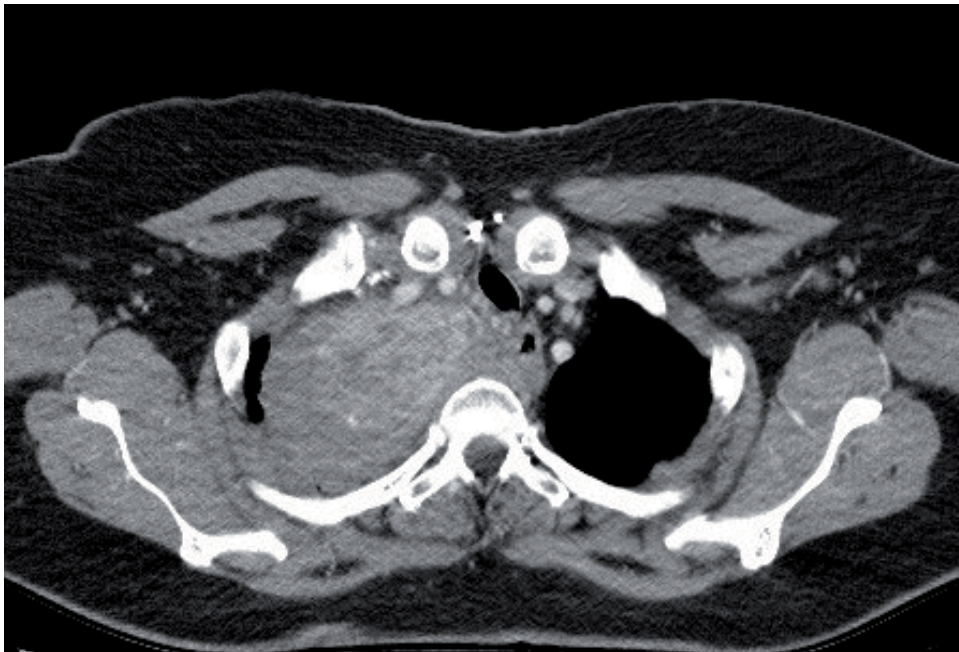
CT scan demonstrating a goitre with extension to the posterior pleura.
